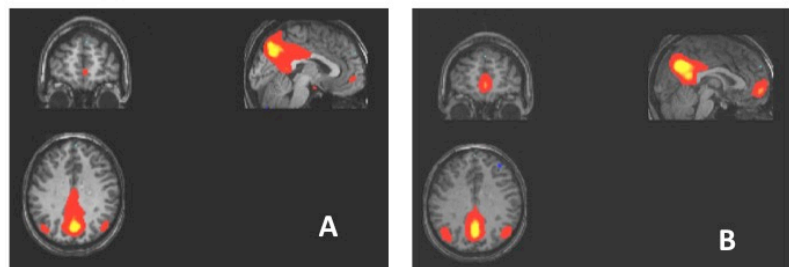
Resting state functional MRI data from time points 1 and 2. Note the emergence of a frontal network at time point 2.
